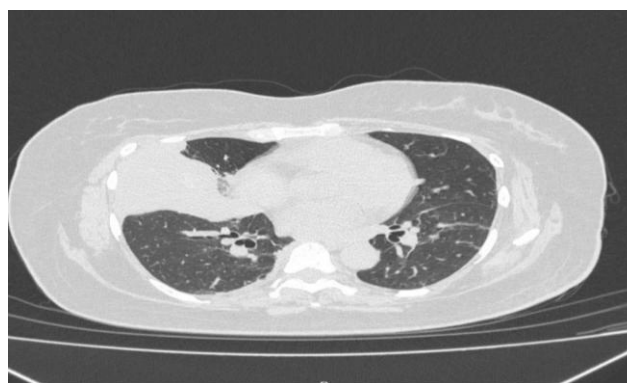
HRCT thorax showing a wedge shaped consolidation without air bronchogram involving the right middle lobe with minimal collapse and adjacent ground glass opacity. It also showed evidence of fluid bronchogram with linear branching hyperdense content in few of the dilated bronchi with minimal central bronchiectatic changes noted in the anterior and posterior segment branch of right upper lobe with adjacent fibrotic changes.
